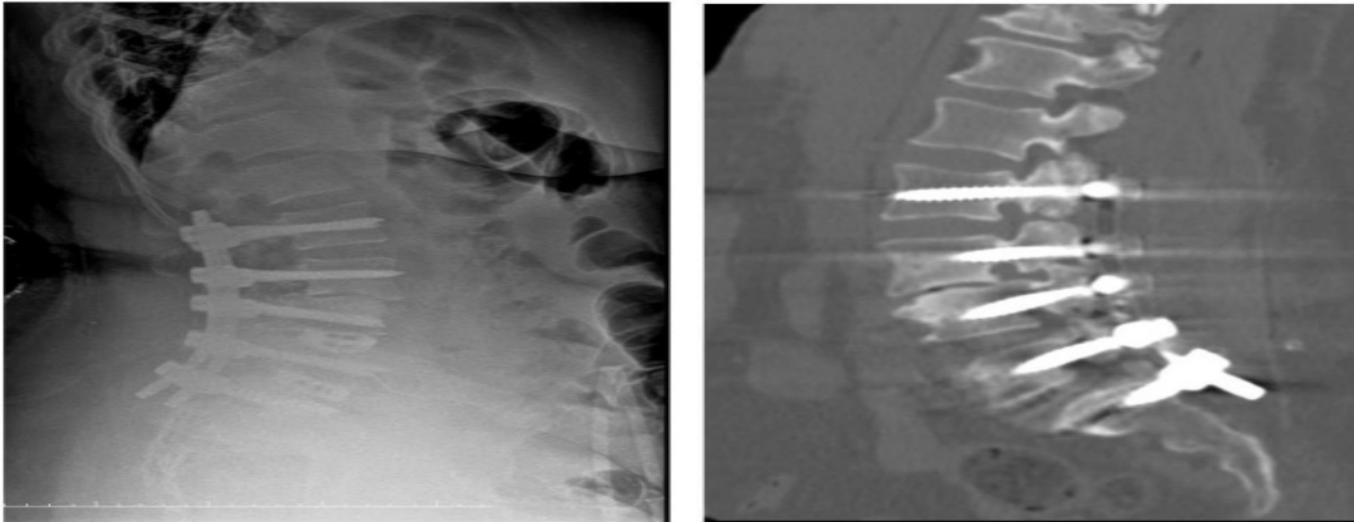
Postoperative lateral x-ray and sagittal CT image. L2-S1 posterior stabilization and fusion with L4-5 and L5-S1 anterior interbody are observed.
